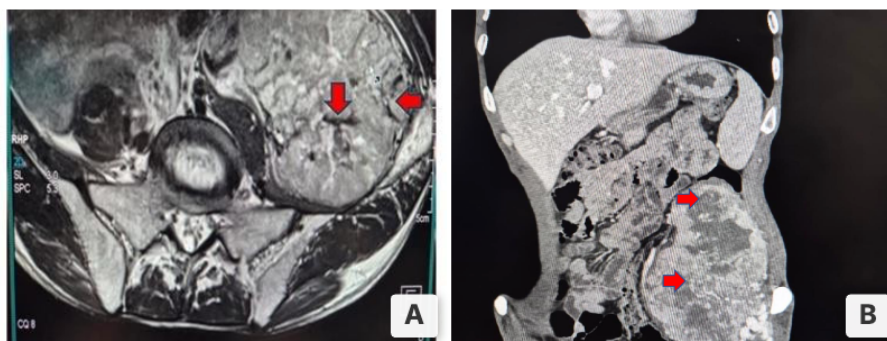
CECT (arterial phase) showing intensely enhancing retroperitoneal mass arising from left iliopsoas region with prominent vascular channels (arrows). B. MRI T2-weighted axial image demonstrating heterogeneous hyperintense lesion with internal flow voids (arrows indicate vascular channels).
